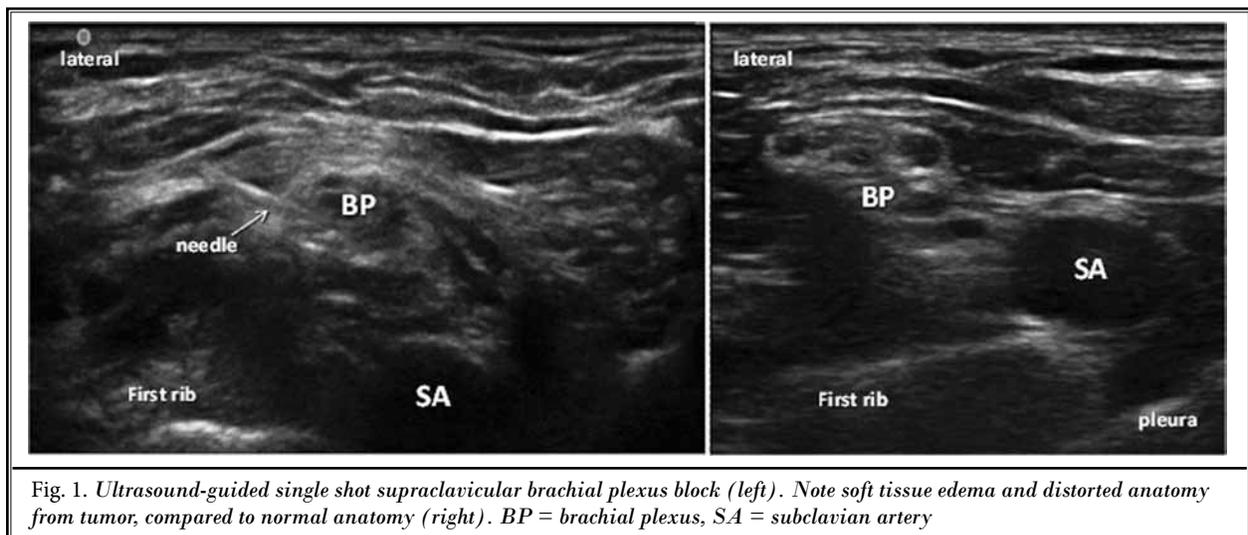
Ultrasound-guided single shot supraclavicular brachial plexus block (left). Note soft tissue edema and distorted anatomy from tumor, compared to normal anatomy (right). BP = brachial plexus, SA = subclavian artery
